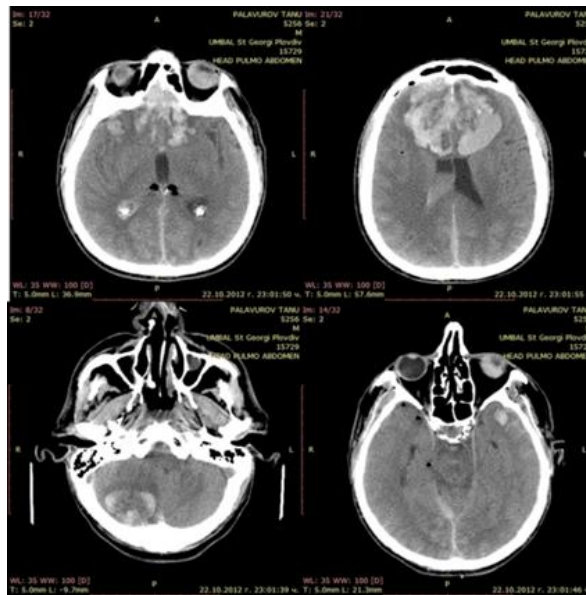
CT images of multiple supratentorial and infratentorial intracerebral hematomas and pneumocephalus
